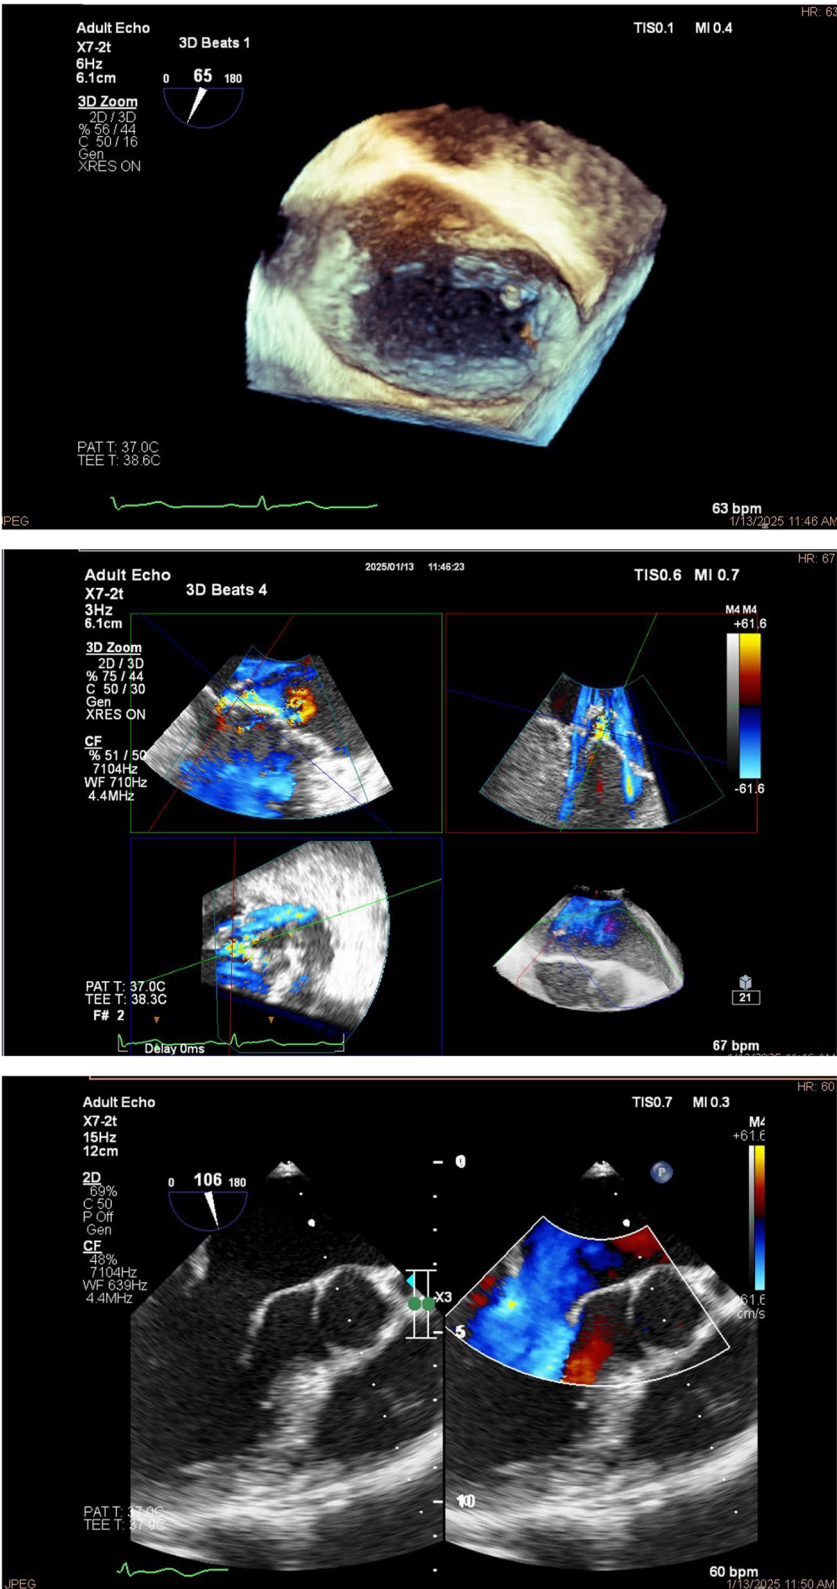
Showing measuring the largest systolic VCA frame by direct planimetry of the signal of color flow Doppler
